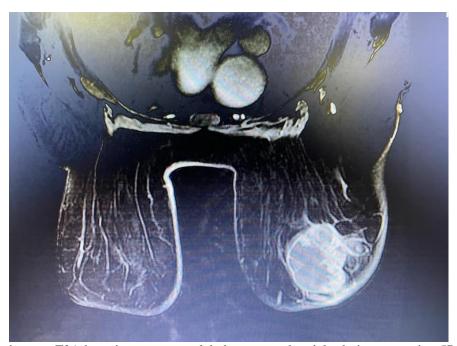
T1A hypointense, T2A hyperintense, macro lobule contoured nodular lesion measuring 57x49 mm in the right breast retro arealar area on dynamic contrast-enhanced breast MRI with peripheral and discontinuous contrast uptake in the post-contrast series.
